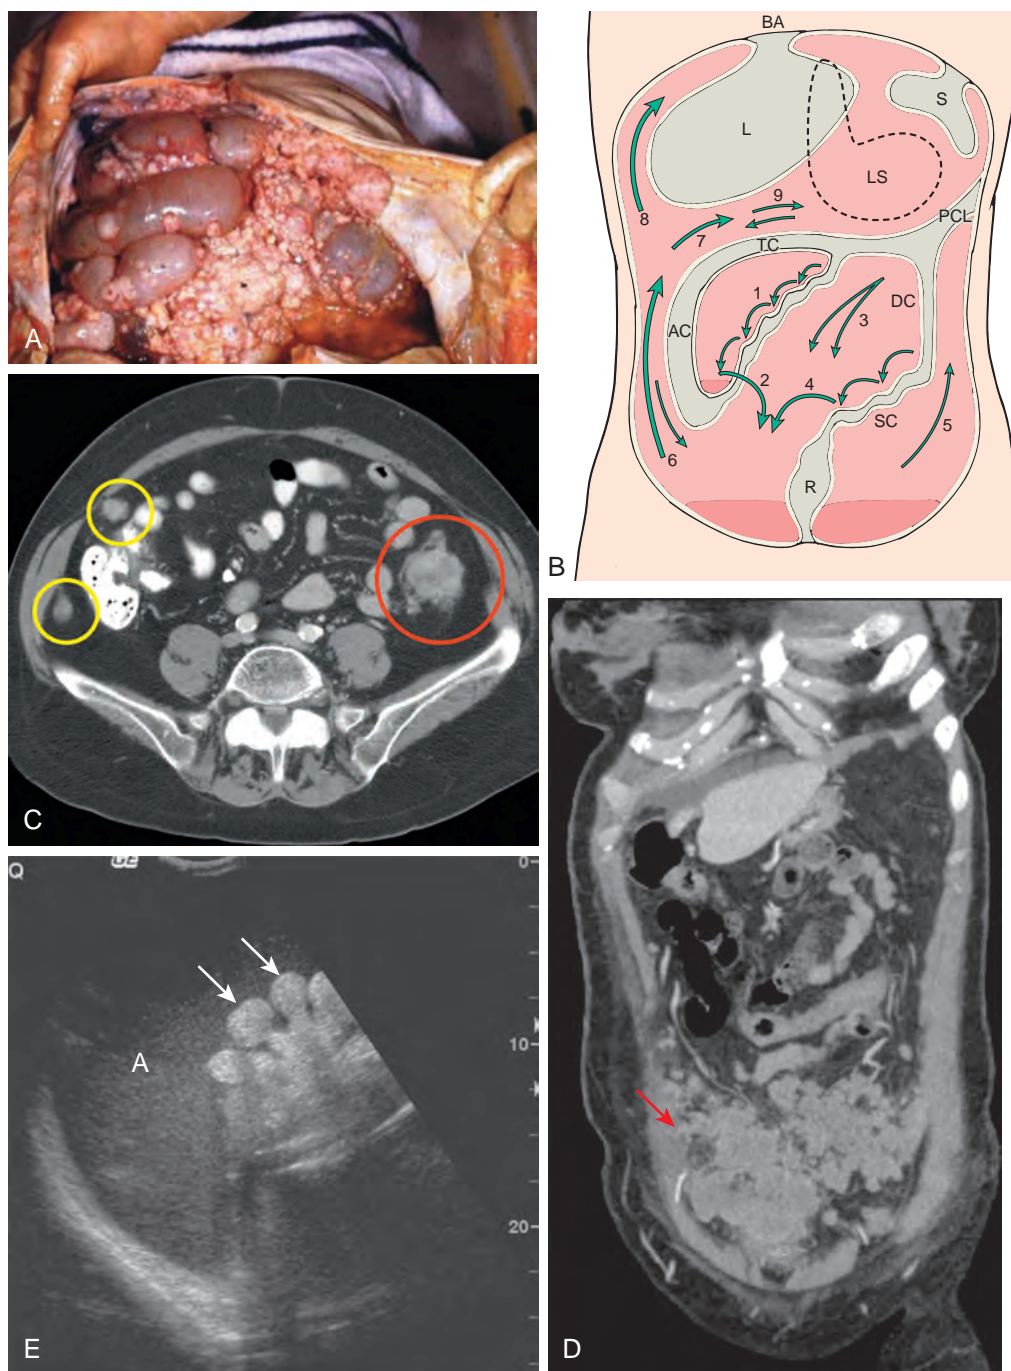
Intraperitoneal spread of tumor: spectrum of imaging findings. A. Gross peritoneal tumor implants are present in a patient with ovarian carcinomatosis. B. Fluid in the right inframesocolic space (1) cascades down the leaves of the small bowel mesentery, pools at the medial aspect of the cecum, and then overflows into the pelvis (2). Fluid in the left inframesocolic space (3) seeks the pelvis directly or is deposited on the superior aspect of the sigmoid mesocolon and then flows into the pelvis (4). Fluid in the pelvis may ascend the left paracolic gutter (5) but is stopped by the phrenicocolic ligament (PCL). Fluid in the right paracolic gutter (6) ascends to Morison's pouch (7) and then to the subphrenic space (8), where it is stopped by the bare area (BA) of the liver (L). There is potential communication with the lesser sac (LS) through the foramen of Winslow (9). AC, Ascending colon; DC, descending colon; R, rectum; S, stomach; SC, sigmoid colon; TC, transverse colon. C. Axial CT scan of a patient with carcinoma of the descending colon (red circle) and tumor implants in the greater omentum (yellow circles) adjacent to the right colon. D. Coronal reformatted CT shows an omental cake resulting from metastases from an ovarian carcinoma. E. Sonogram showing malignant ascites (A) contains fine, low-level echoes with matting of the bowel loops (arrows) centrally and posteriorly. (B modified from Meyers MA: The spread and localization of acute intraperitoneal effusions. *Radiology* 95:547-554, 1970; and from Meyers MA: Metastatic seeding along small bowel mesentery: Roentgen features. *Am J Roentgenol Radium Ther Nucl Med* 123:67-73, 1975.)
